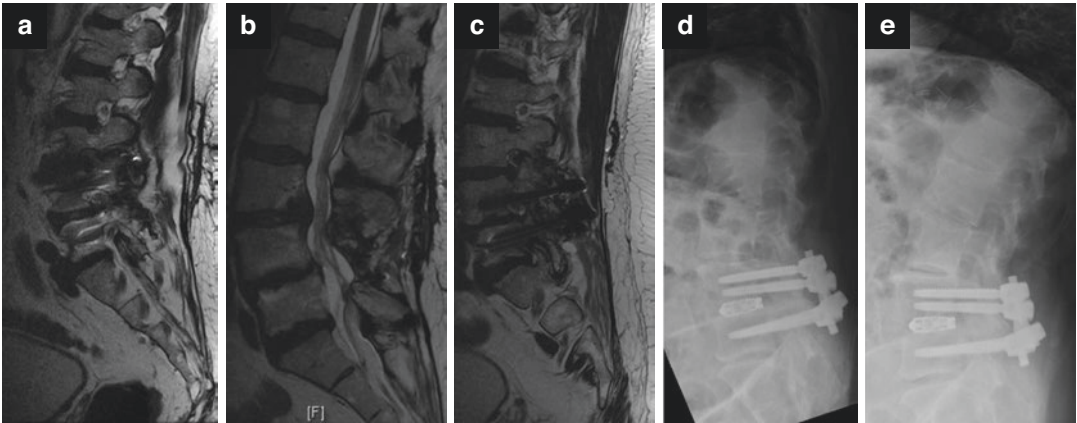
T2-weighted MRI scans ((a) left parasagittal, (b) midline sagittal, and (c) right parasagittal) demonstrating the degenerative disc disease above and below the previous L4–5 fusion. There is severe left-sided foraminal stenosis at L3–4 and severe right-sided L5–S1 foraminal
